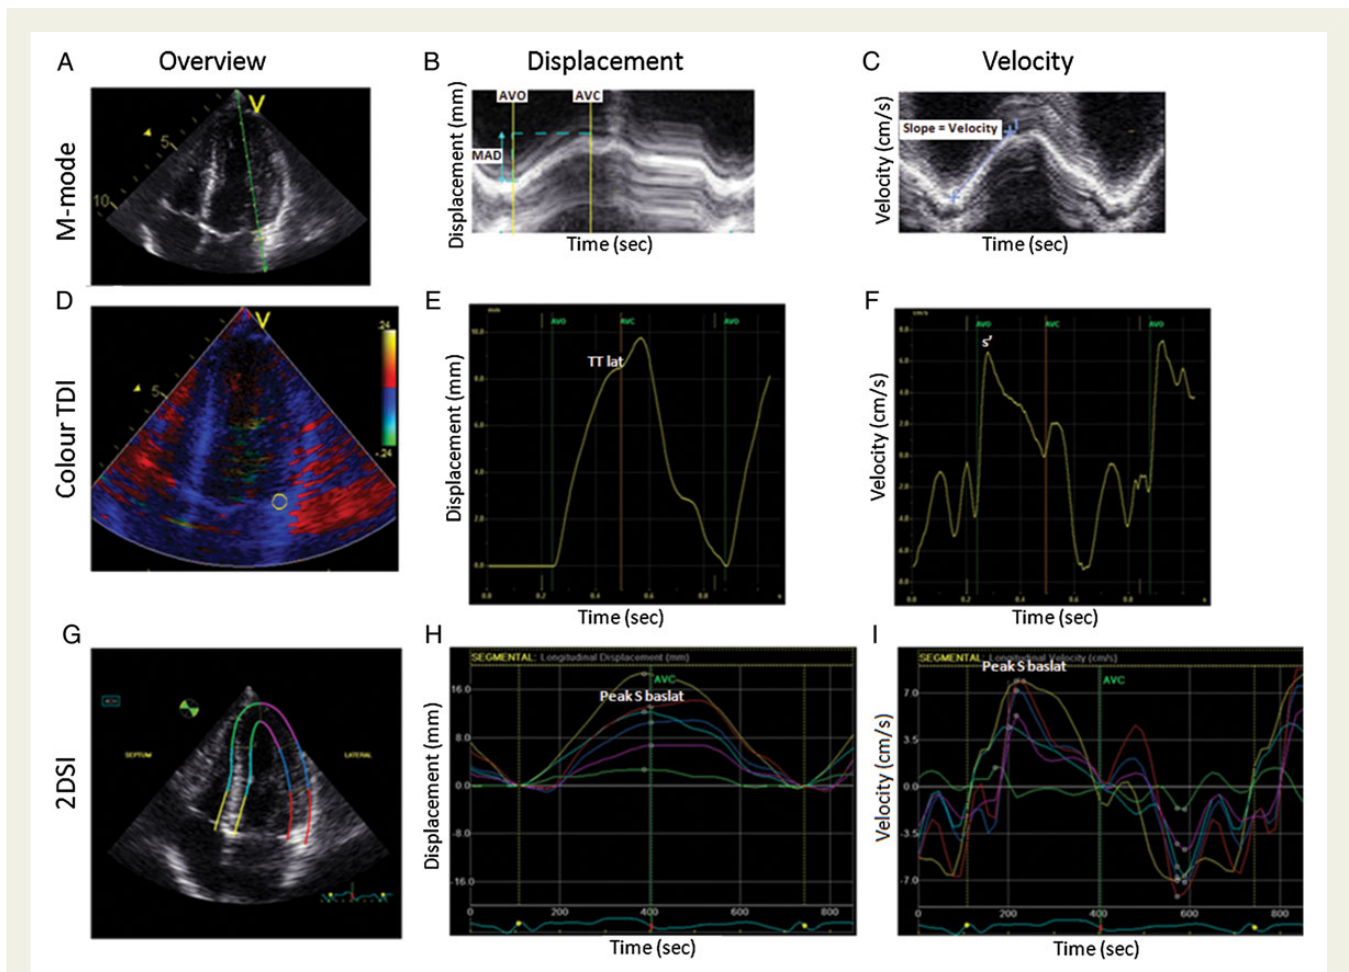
(A) Lateral mitral annulus displacement (MAD) using conventional M-mode measured in the 4-chamber view. (B) By placing the M-mode cursor at the lateral border in the mitral annulus plane, an image of lateral MAD was obtained. The total MAD was measured from the lowest to the highest point of contraction, excluding post-systolic contractions (between AVO and AVC times, respectively). (C) Systolic velocity was determined by measuring the gradient between the highest and lowest points. (D) Sample areas used to determine lateral MAD by colour TDI were placed in the lateral basal segment just proximal to the mitral annulus. (E) Integration of colour TDI velocity curves allowed for the assessment of systolic longitudinal displacement. Post-systolic contraction was not included in total MA displacement measurements. (F) The determination of left ventricular longitudinal velocity (s') in the lateral wall in the apical 4-chamber view. (G) 2DSI in the apical 4-chamber view. (H) By tracking a speckle from frame-to-frame, myocardial motion was assessed and total lateral displacement was determined. (I) Systolic tissue velocity determined by 2DSI. Modified from de Knecht *et al.*¹⁹
